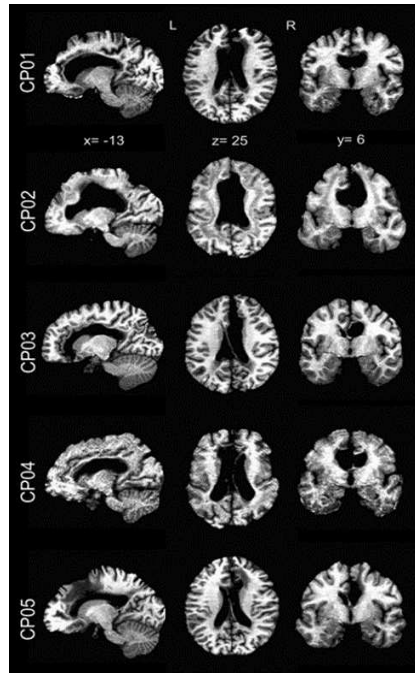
Anatomical MRI (Magnetic Resonance Imaging) images of split-brain patients. For each patient (CP01– CP05) sagittal, axial, and coronal MRI images are shown in Micro and Nano Imaging (MNI) space. It is possible to appreciate the complete absence of the CC in all cases (Avvenuti et al., 2020).
